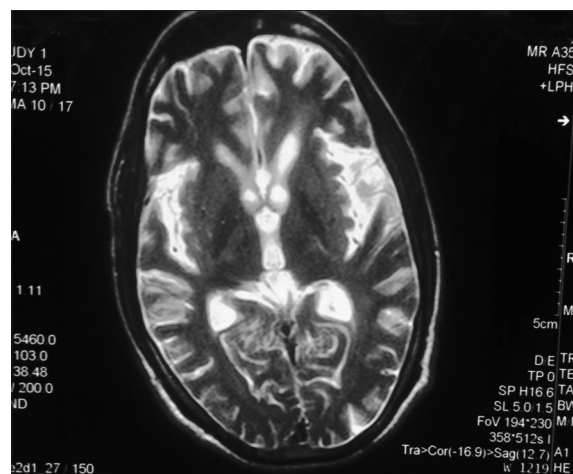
T2-weighted image of magnetic resonance imaging brain showing encephalitis
